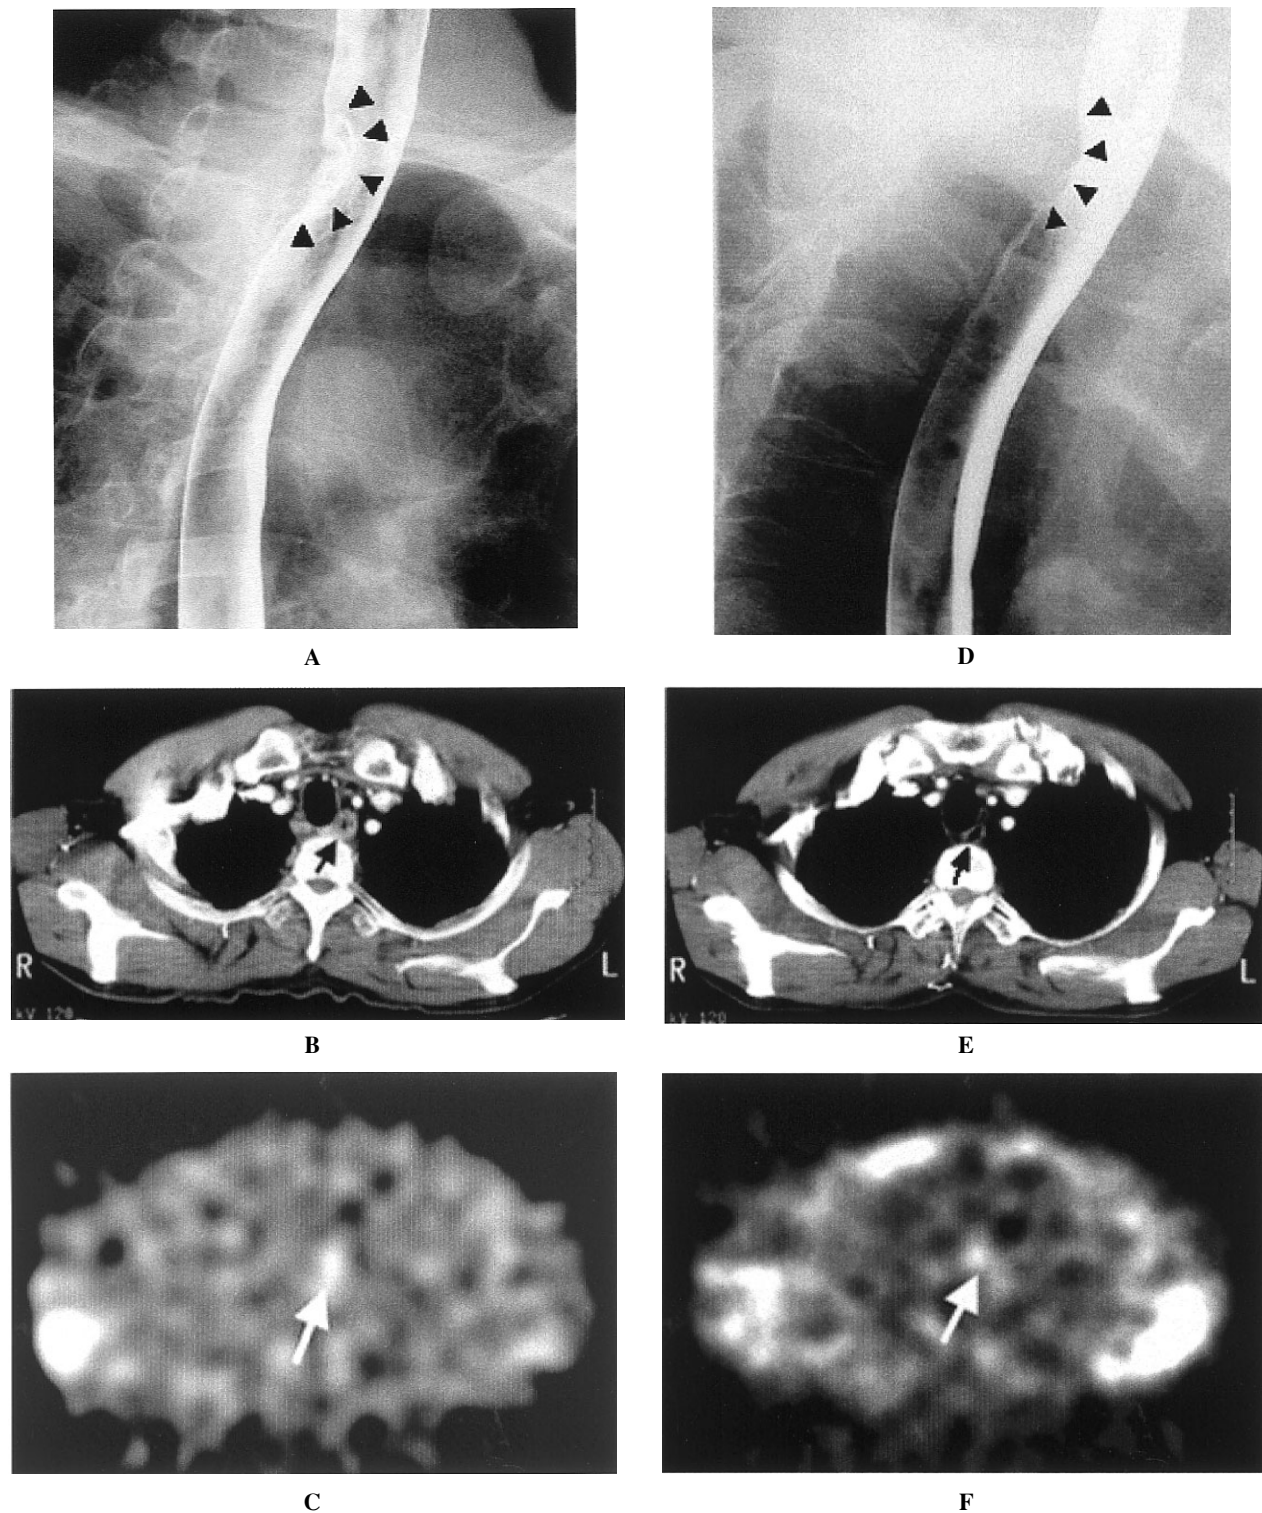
A 55-year-old man with advanced esophageal cancer who had a pathologically poor response (grade 1a) after chemoradiotherapy. A, Pre-chemoradiotherapy barium swallow showed an advanced cancer in the upper third of the esophagus. B, Pre-chemoradiotherapy CT demonstrated a thickened esophageal wall. C, Pre-chemoradiotherapy SPECT showed abnormal uptake in the esophageal cancer. D, Post-chemoradiotherapy barium swallow showed an approximately 50% decrease in tumor volume. E, Post-chemoradiotherapy CT showed that contrast enhancement in a part of esophageal wall was suspected. However, whether residual tumor viability would be present was uncertain because there was no detectable wall thickening at the tumor site. F, Post-chemoradiotherapy SPECT revealed residual uptake at the tumor site.
